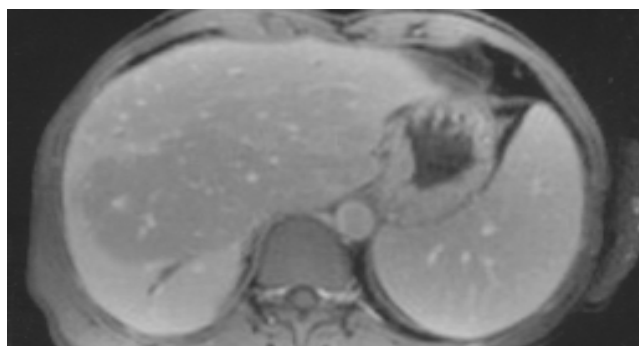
MRT of patient 2 (T1-weighted after contrast medium) showing an area centrally in the liver with reduced signal intensity, a dilatation of the bile duct in segment 6, and splenomegaly.
